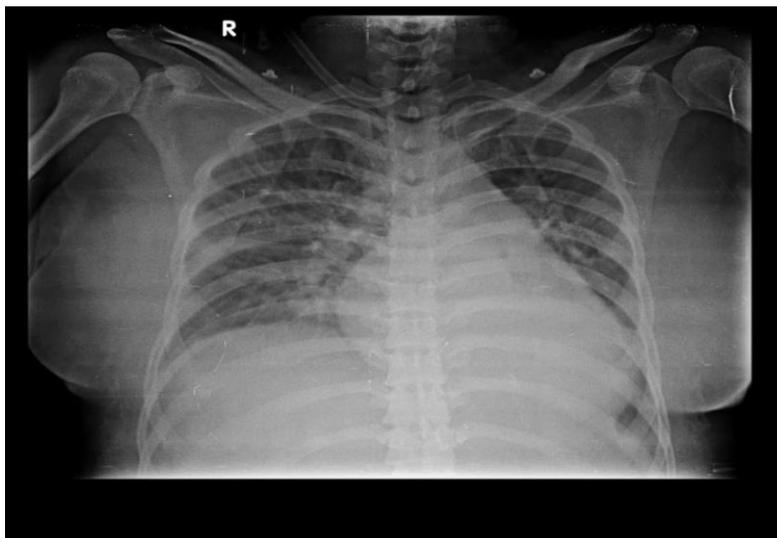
Chest X-Ray showing Cardiomegaly and Pleural Effusion
